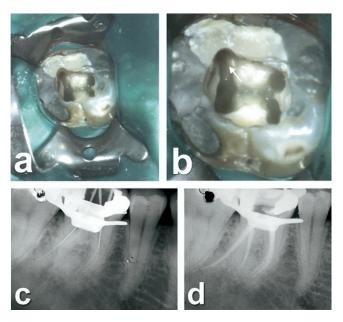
(a, b) occlusal view of the pulp chamber floor with the orifice of the radix entomolaris (arrow). A distolingual extension of the opening cavity is made for better access and vision of the additional canal. (c) Length determination radiograph. The radix entomolaris is invisible because of superposition of bone. (d) Postoperative radiograph with the radix entomolaris in the middle.
